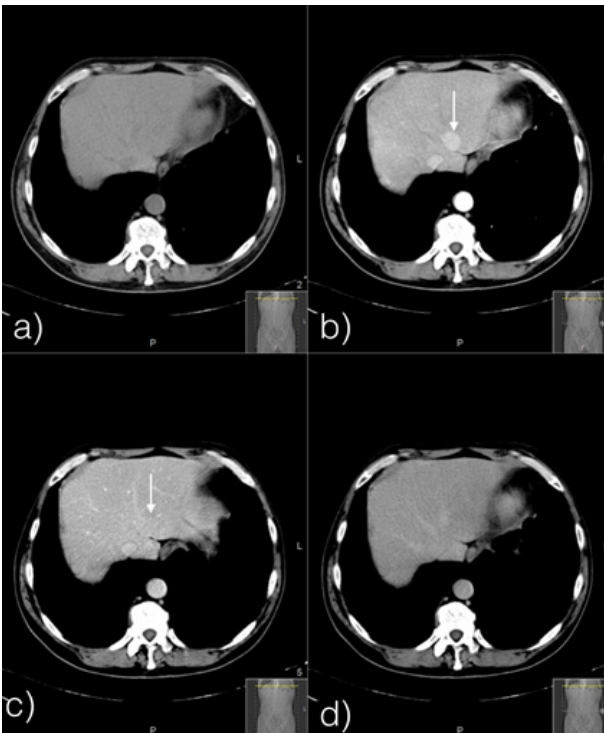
Contrast enhanced abdominal CT depicting the nodule (arrow) in segment 2 – a) on the unenhanced image the nodule is hard to identify; b) arterial phase shows clear homogenous enhancement of the nodule that fades on portal (c) and late (d) phases.
